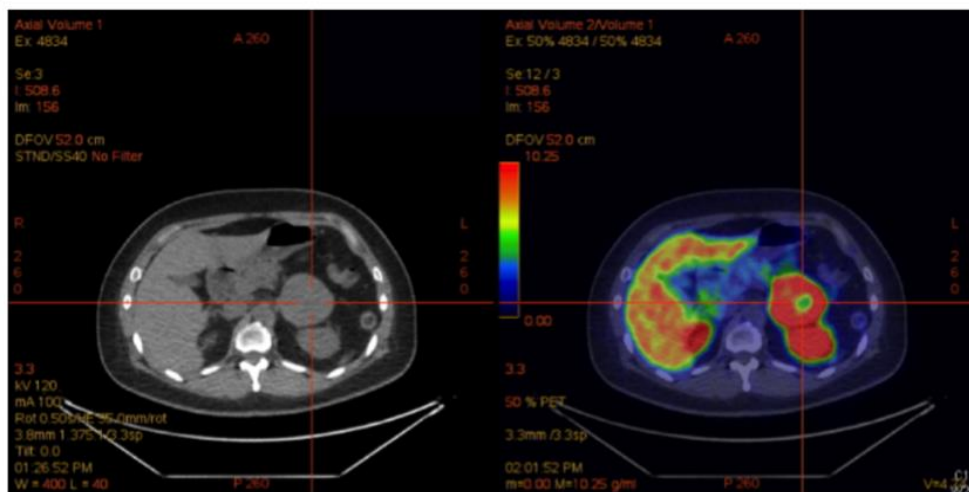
DOTATATE PET/CT images. Large DOTATATE-avid left adrenal mass.
